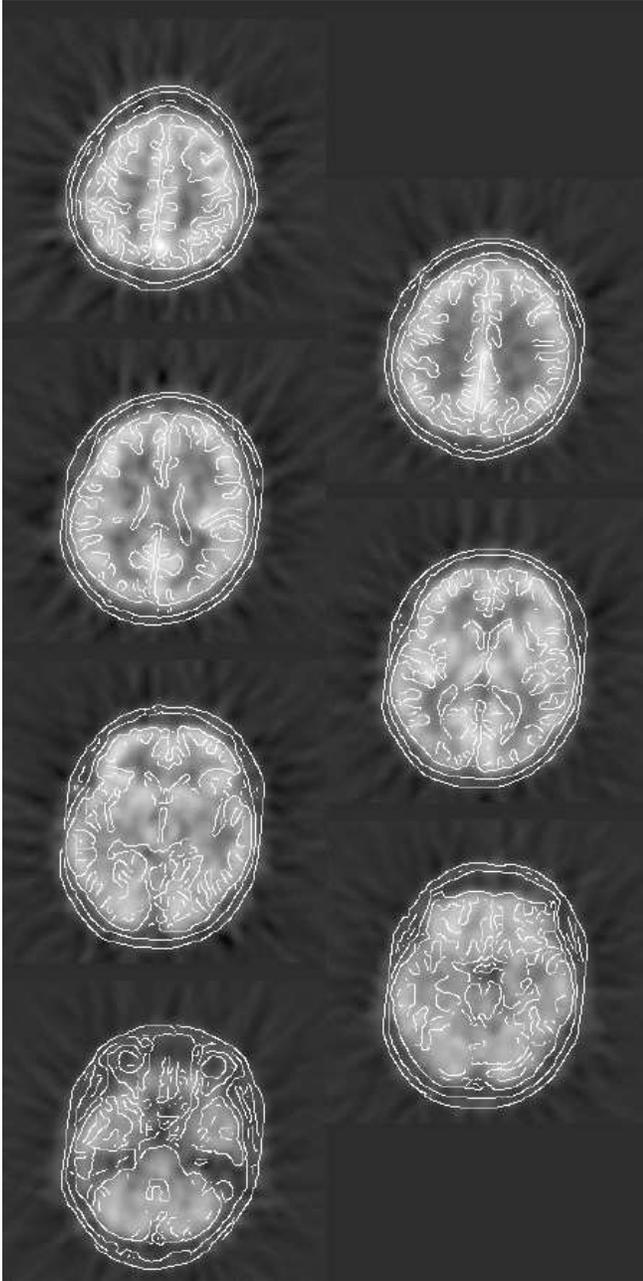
A final configuration for MR-PET registration by maximization of mutual information. The original PET slices are shown with the edges from the registered MRI overlaid
